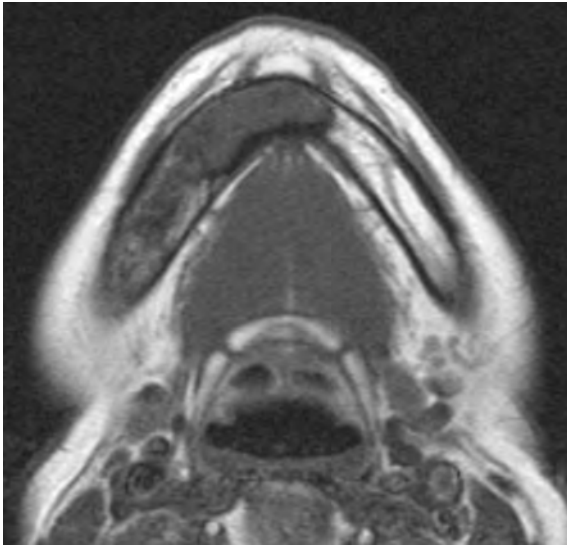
Primary Burkitt's lymphoma of the mandible. Axial T1-weighted non-enhanced MR image shows replacement of the normal fatty marrow by a low signal intensity mass in the median and right part of the mandible, with expansion of the medullary cavity
